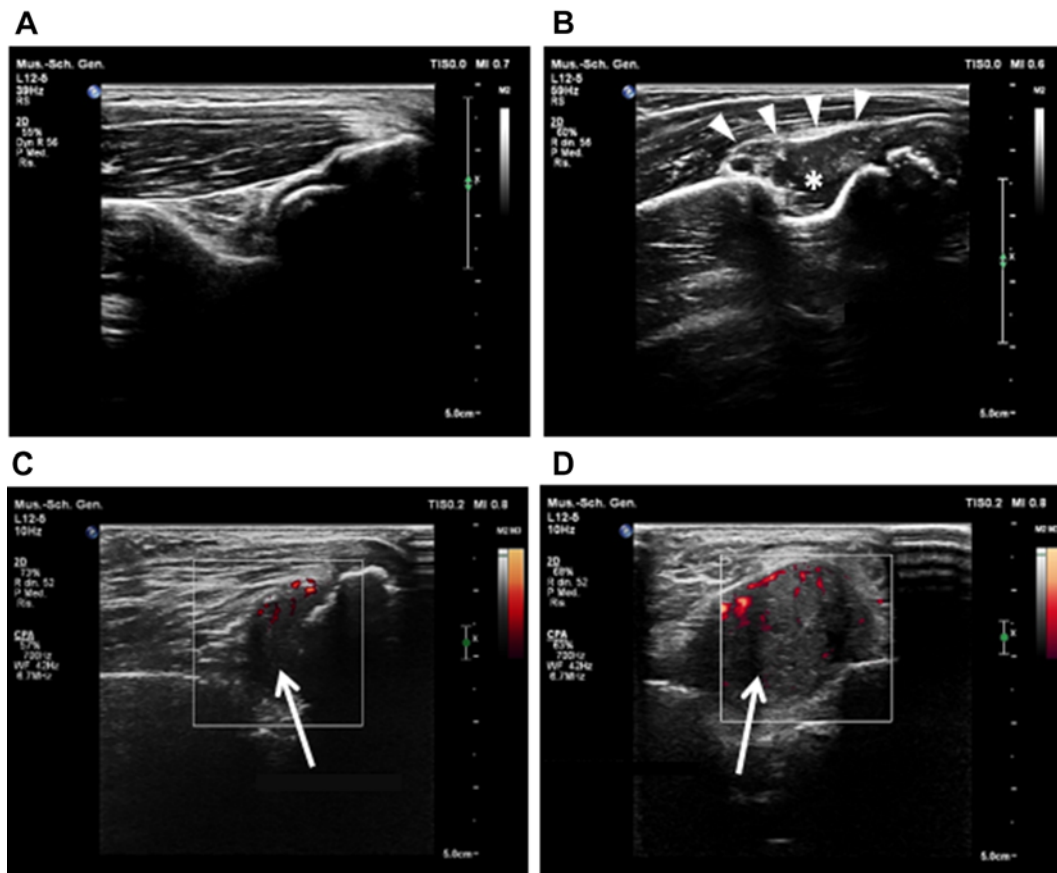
FIGURE Longitudinal scan of the posterior recess of the elbow. (A) A normal elbow. (B) Joint bleeding in the posterior recess of the elbow of an adult person with severe hemophilia and hemophilic arthropathy: the joint capsule is distended (arrowheads) by an inhomogeneous isoechoic corpusculated fluid (asterisk) with speckles that swirl at dynamic maneuvers. (C) Synovial hyperplasia (arrow) with power Doppler signal in the posterior recess of the elbow of a different adult patient with hemophilic arthropathy in a longitudinal scan and (D) in a transversal scan. The presence of a Doppler signal in (C and D) suggests that the capsule distension is due to solid and vascularized synovial tissue and, therefore, allows for the exclusion of joint bleeding.
